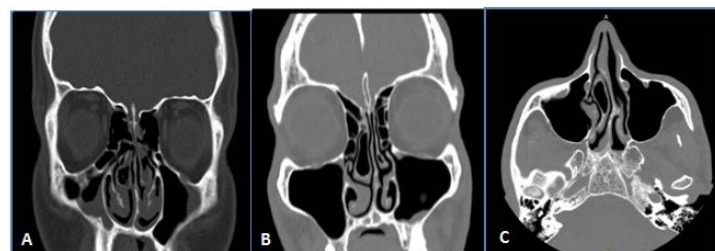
CT scan coronal images: Bilateral concha bullosa, with bilateral maxillary sinusitis (A), concha bullosa right side with left maxillary sinusitis (B), axial image, right concha bullosa (C).
